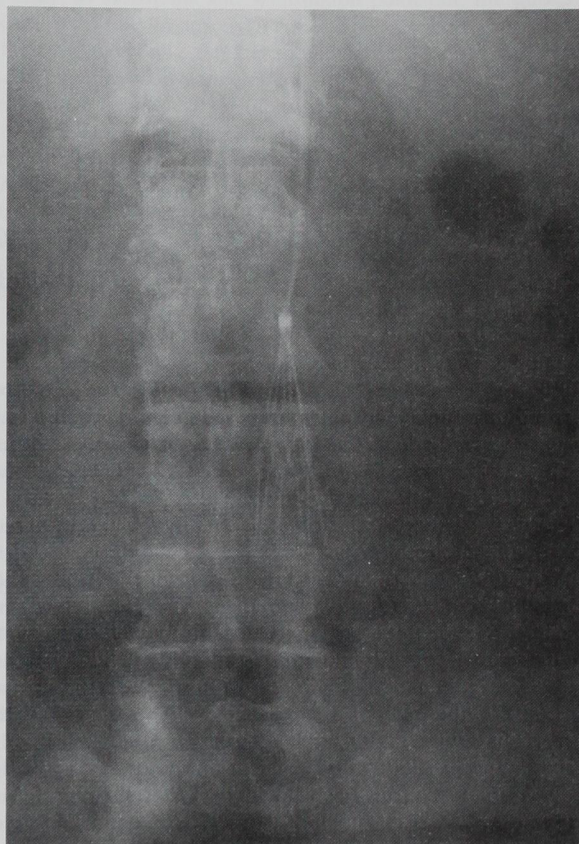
Anterior-posterior radiograph of the abdomen demonstrating the J-wire engaged with the apex of a Greenfield-type filter located in the inferior vena cava.
